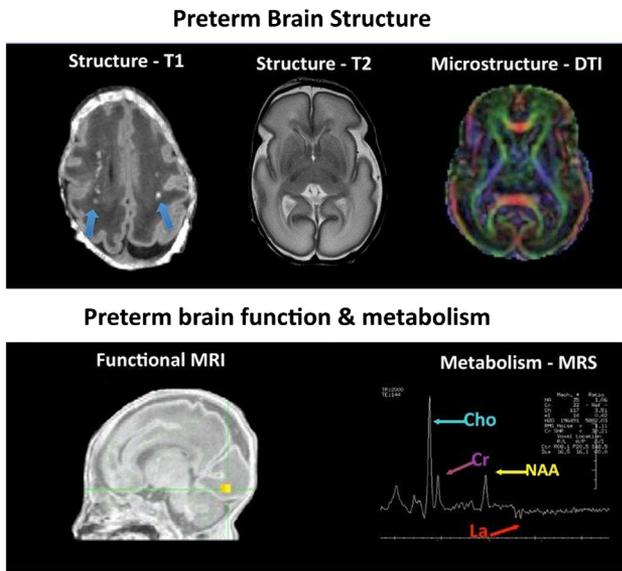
Brain structure, function, and metabolism measured in preterm-born infants. Brain imaging data acquired in preterm-born infants (<32 weeks). Information about brain macrostructure or microstructure can be obtained through anatomical MRI (T1- and T2-weighted images) and diffusion-tensor imaging (DTI). Top left: T1-weighted imaging permits the identification of white-matter injury as areas of abnormal hyperintensity in the white matter (blue arrows). Data were acquired in a 31-week-old neonate. Top middle: T2-weighted MRI of a 29-week-old infant. T2-weighted images may allow better assessment of cortical anatomy. Top right: DTI in a 28-week-old infant. Color maps represent the diffusion of water along the principle eigenvectors in white-matter fiber pathways and cerebral cortex (red: left to right; green: anterior to posterior; blue: superior to inferior). MRI sequences can also be used to study brain function and metabolism. Bottom left: Functional MRI demonstrating activation in the primary visual cortex in a preterm-born infant. Bottom right: Measures of brain metabolites that are indices of neuronal maturation. Cho, choline; Cr, Creatine; La, lactate.
